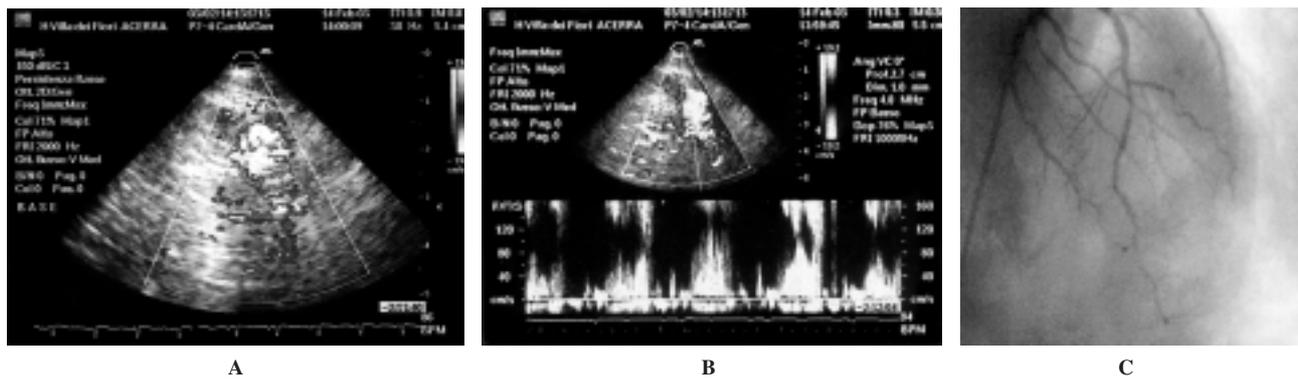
A and B: direct and indirect Doppler signs indicative of a significant (> 70% diameter reduction) left anterior descending coronary artery stenosis; C: coronary angiography showing a proximal left anterior descending coronary artery patency but a distal severe stenosis (80%).
